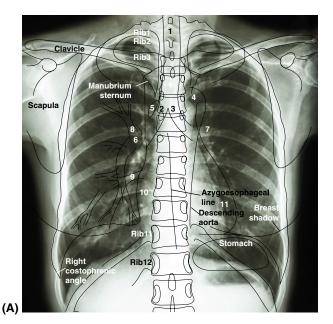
Normal chest radiograph. (A) PA view. (B) Lateral view. (A) © stockdevil/iStock/Thinkstock; (B) © Lukasz Panek/iStock/Thinkstock.
